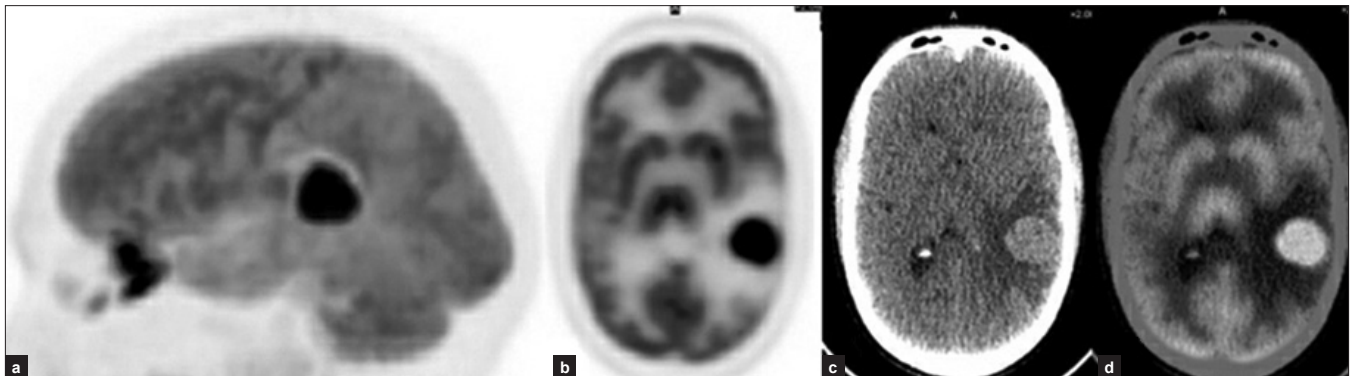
50-year male with malignant melanoma of the anal canal; (a) Lateral MIP image of the brain shows a hyper-metabolic focus; (b, c, d) Axial plain PET, CT and fused PET/CT images localize the hyper-metabolism to a well-defined hyper-dense lesion in the left parietal region with effacement of atrium of left lateral ventricle with surrounding edema
